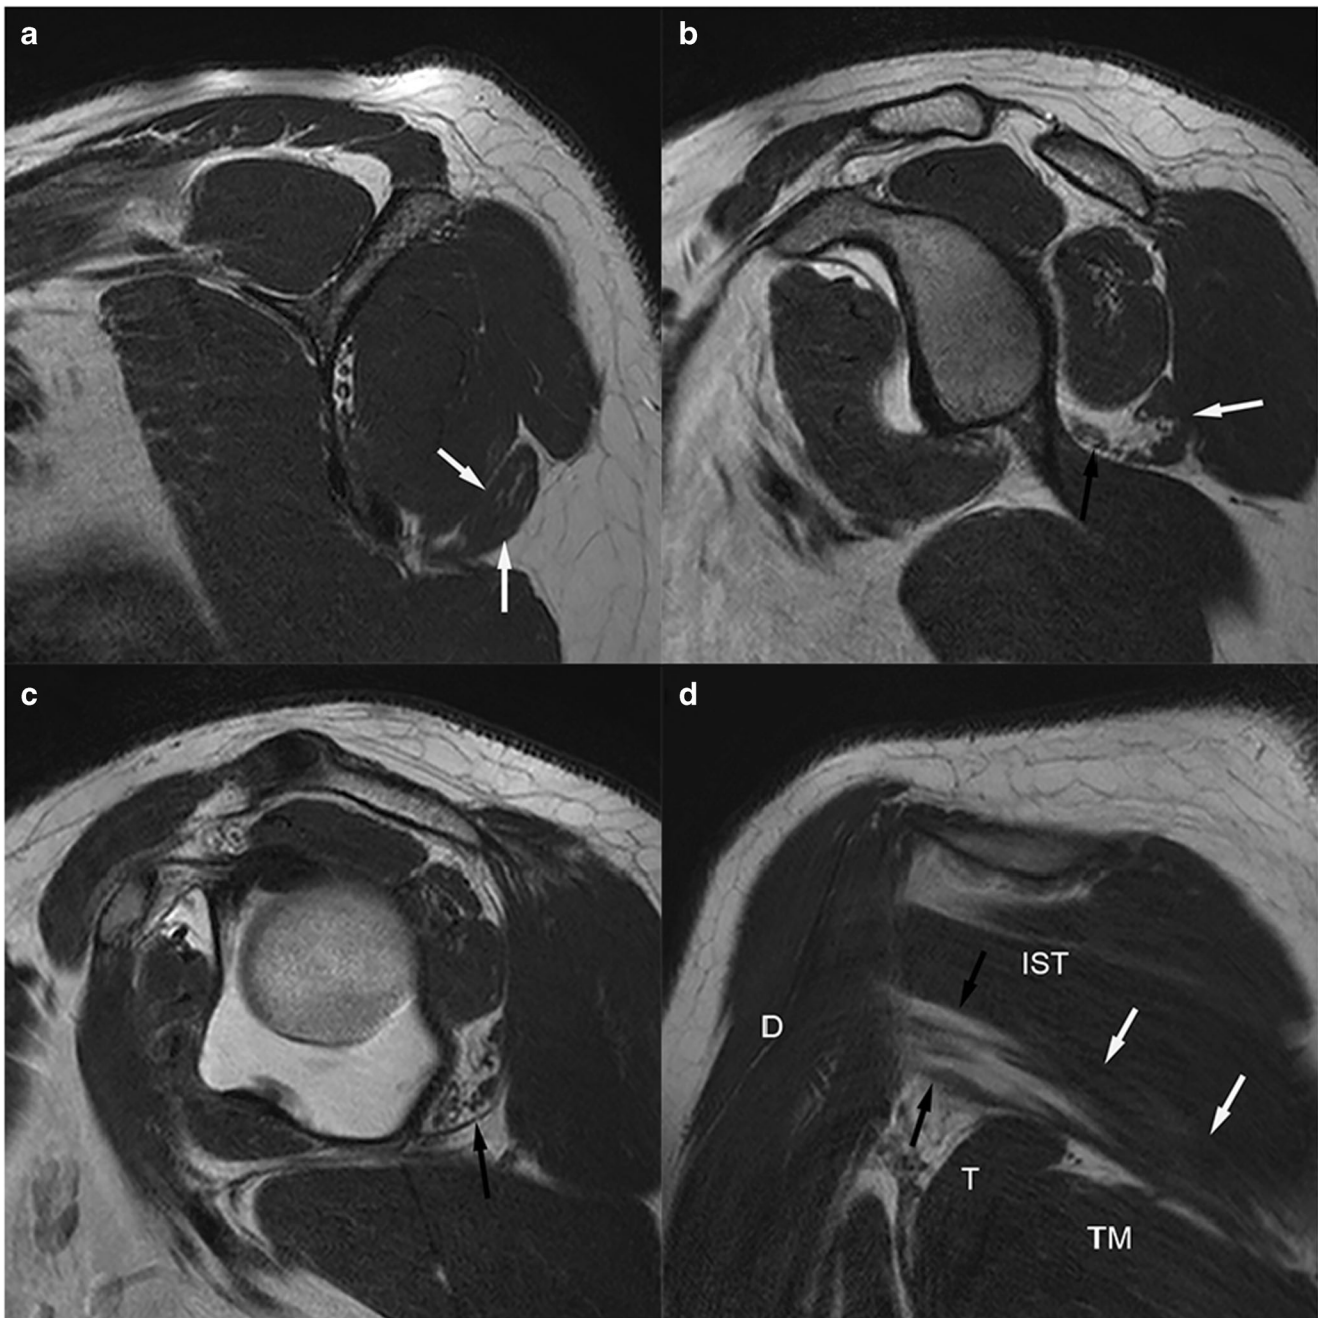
Lateral–ventral dominant partial pattern of isolated teres minor atrophy in a 19-year-old woman. Sequential oblique sagittal T2-weighted images (TR/TE, 3,298/80 ms) of the shoulder are shown, at a the scapular Y, b the glenoid face, c the coracoid process and humeral head, and d an oblique coronal T2-weighted image (TR/TE, 2,535/80 ms)
